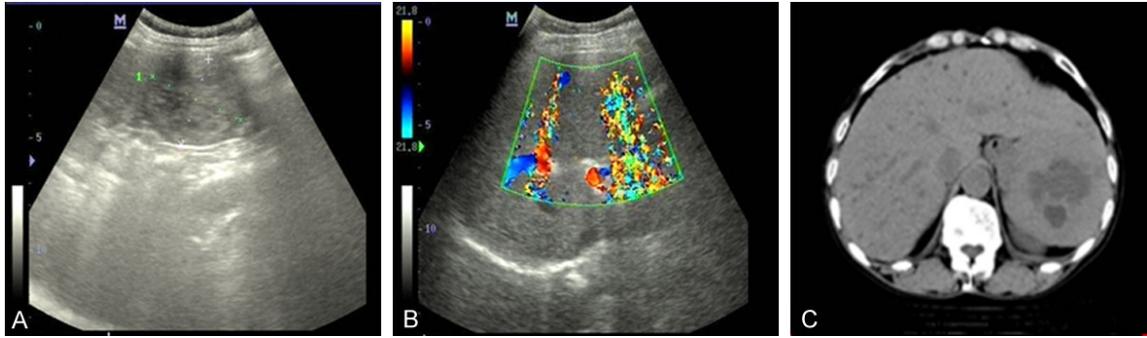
A: Grayscale sonogram showing multiple masses of mixed echogenicity scattering in the spleen (Case 1); B: Color Doppler image showing multiple heterogeneous lesions (Case 1); C: Unenhanced CT showing splenomegaly with multiple hypodense nodules scattering in the spleen (Case 2).
